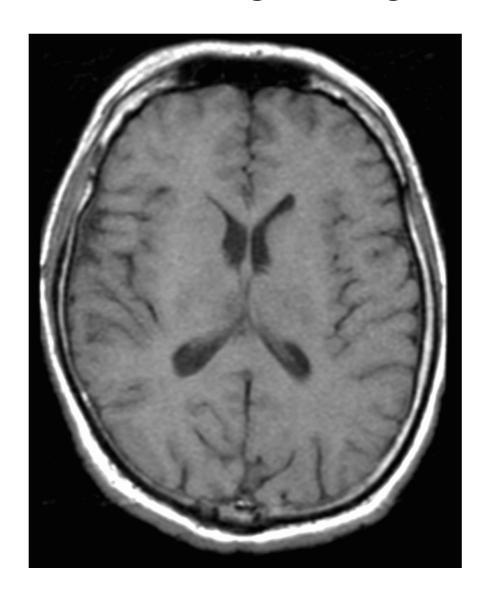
The T1-weighted spin echo axial brain image obtained with TR= 549 msec and TE= 11 msec demonstrates bright image intensity for short-T1 tissues (white matter and fat) and dark intensity for long-T1 tissues (cerebrospinal fluid).
